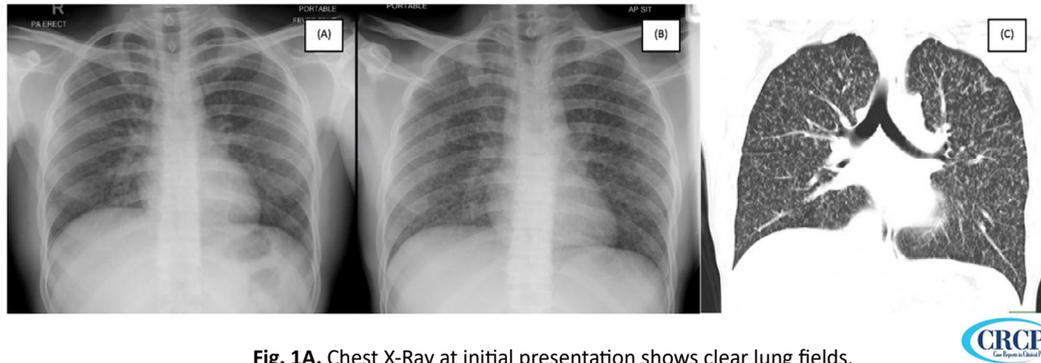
Chest X-Ray at initial presentation shows clear lung fields.
